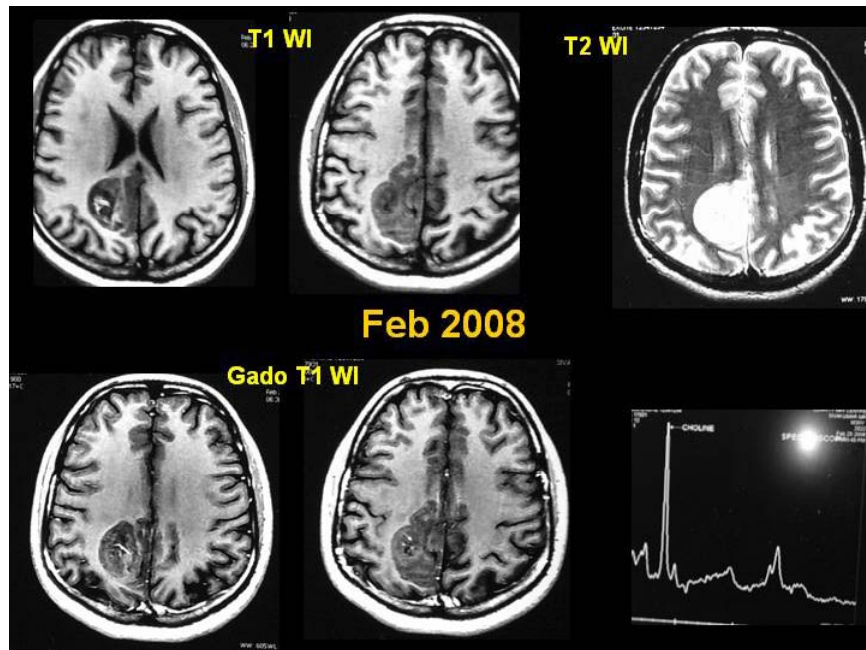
Preoperative MRI shows patchy enhancing lesion in right parietal cortex- surgery done ; biopsy :neuroblastoma (grade III)
